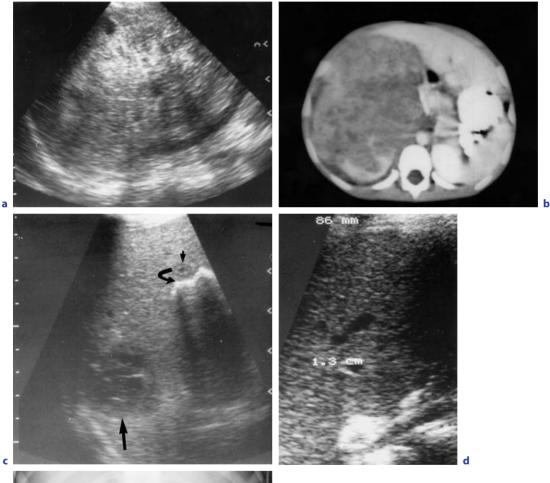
a Ultrasonography and b CT scan shows a large mass arising from the right kidney. A Wilms' tumor was confirmed at biopsy. There were also tumor nodules present in the adjacent liver. c Follow-up ultrasonography at 6 weeks after chemotherapy shows a residual tumor nodule in the posterior aspect of the right lobe of the liver (black arrow). There is an area of increased echogenicity with some shadowing in a more anterior location in keeping with the development of calcification at the site of a second nodule (curved arrow) close to the gall bladder (arrowhead). d Follow-up ultrasonography at 2.5 years. There is an area of increased echogenicity (between cursors) in the inferior aspect of the right lobe of the liver, the site of a previous tumor nodule. e Calcification on plain radiography at two liver tumor nodule sites (arrows)
